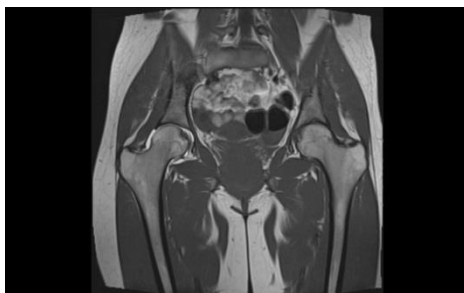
Coronal MRI of the hips and pelvis
